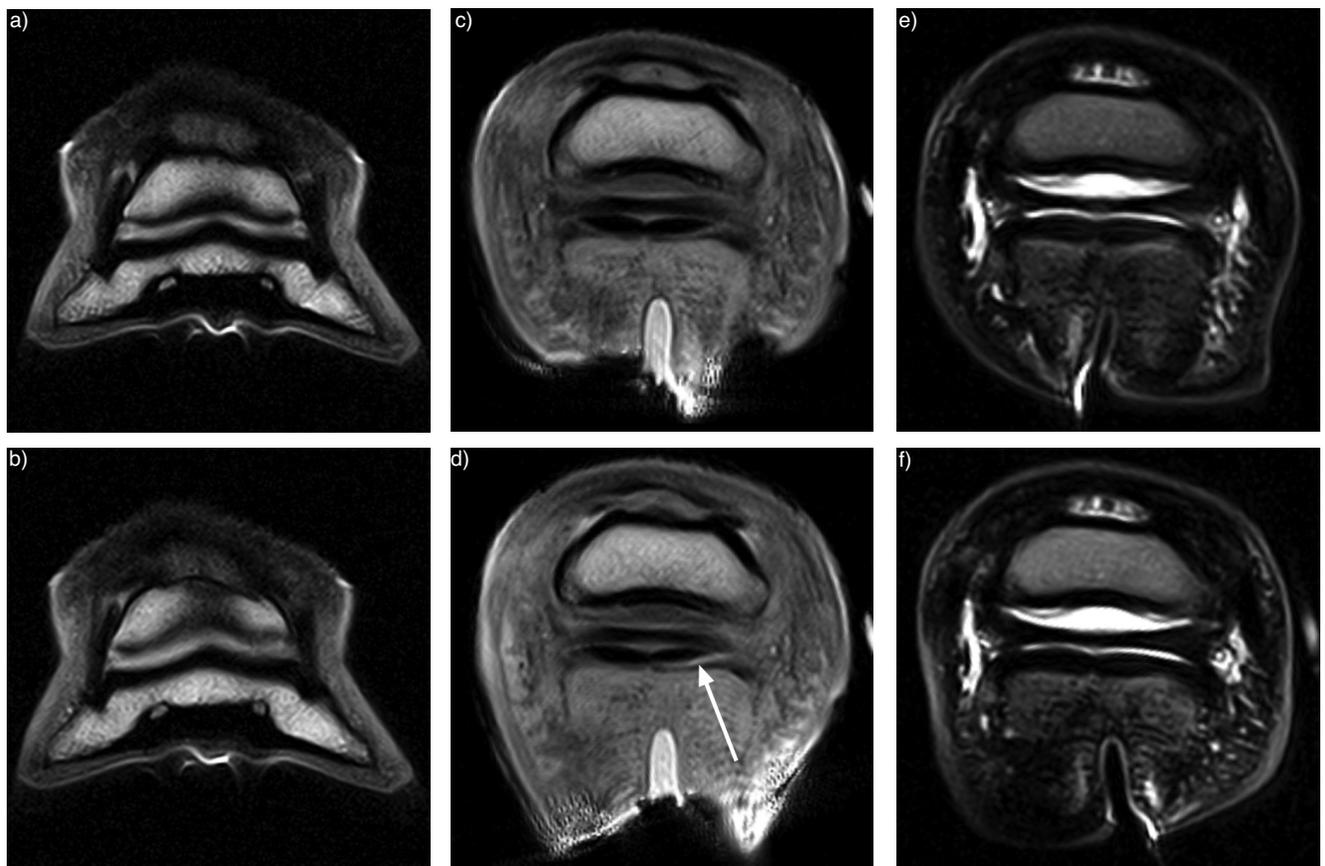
Effect of rotation on the signal intensity in different pulse sequences. Dorsal spin echo T1-weighted images at the level of the collateral ligaments of the distal interphalangeal joint (a and b), transverse gradient echo 3D T1-weighted (c and d) and spin echo T2-weighted images (e and f) at the level of the collateral sesamoidean ligament of a foot with normal conformation (Foot 1). Images a, c and e were obtained at the 0° position whereas images b, d and f were obtained with 15° of external rotation. Both collateral ligaments of the distal interphalangeal joint present a hypointense signal at the 0° position (a). There is no change in signal intensity in the collateral ligaments with 15° of external rotation (b). A linear hyperintense signal (arrow) is present at the palmar aspect of the lateral lobe of the deep digital flexor tendon with 15° of external rotation on the T1-weighted image (d) but not on the T2-weighted image (f).
